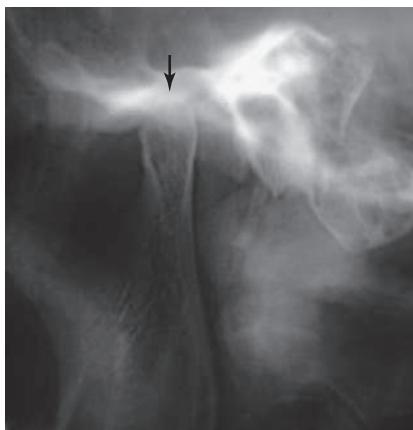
A transcranial radiograph shows the lateral pole of the mandibular condyle (arrow).
